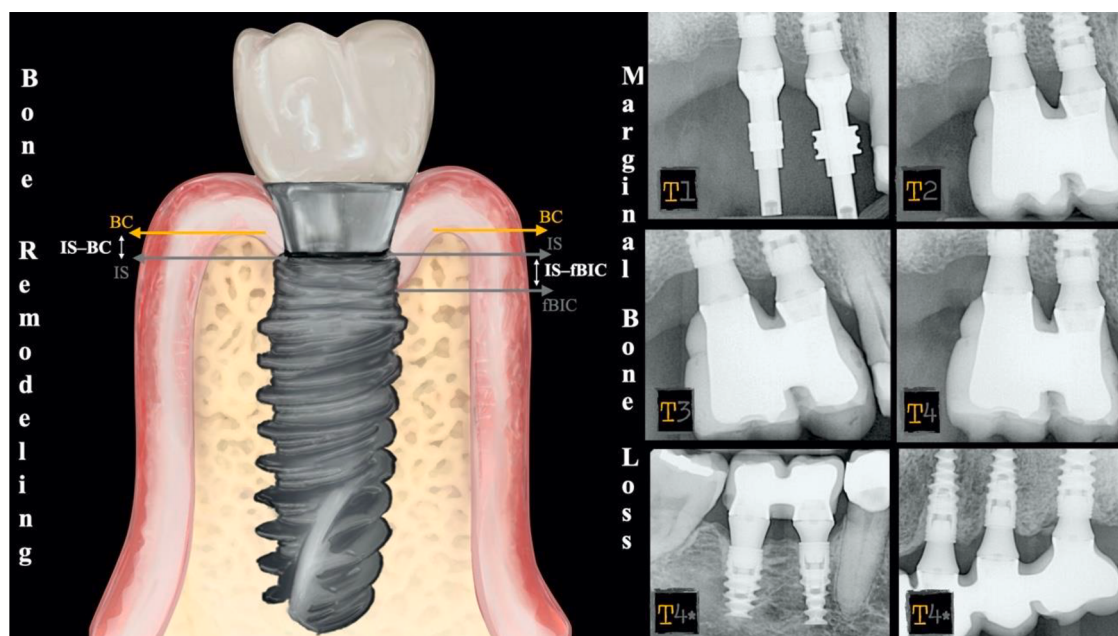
Distances (IS–BC and IS–fBIC) and reference points used for calculation of bone remodelling and MBL. Clinical case (T1–T4) radiograph of a patient at the time of impression taking; (T2) radiograph after 6 months; (T3) radiograph after 1 year, and (T4) radiograph after 2 years. (T4*) Check-up of several patients after at least 2 years of follow up.
